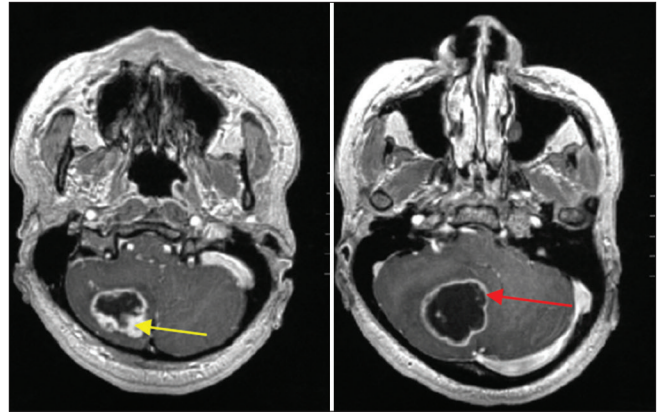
Preoperative magnetic resonance imaging (MRI). Axial MRI post gad showing the cystic lesion with enhancing mural nodule (yellow arrow), and enhancement of the cystic wall (red arrow).
